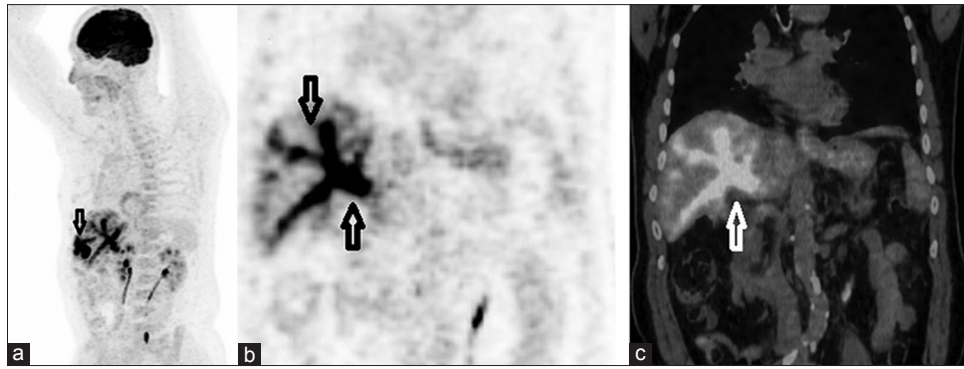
^{18}F -FDG PET [maximum intensity projection (MIP)] images showed focal increased uptake in the lesion (SUVmax: 29) located in the right liver lobe as continuation of this lesion (a) Coronal PET images of distal branches of the right portal vein, the main trunk of the right portal vein, the main trunk of the left portal vein, and the main trunk of the right portal vein showing diffuse ^{18}F -FDG (SUVmax: 18.9) uptake (b and c)
